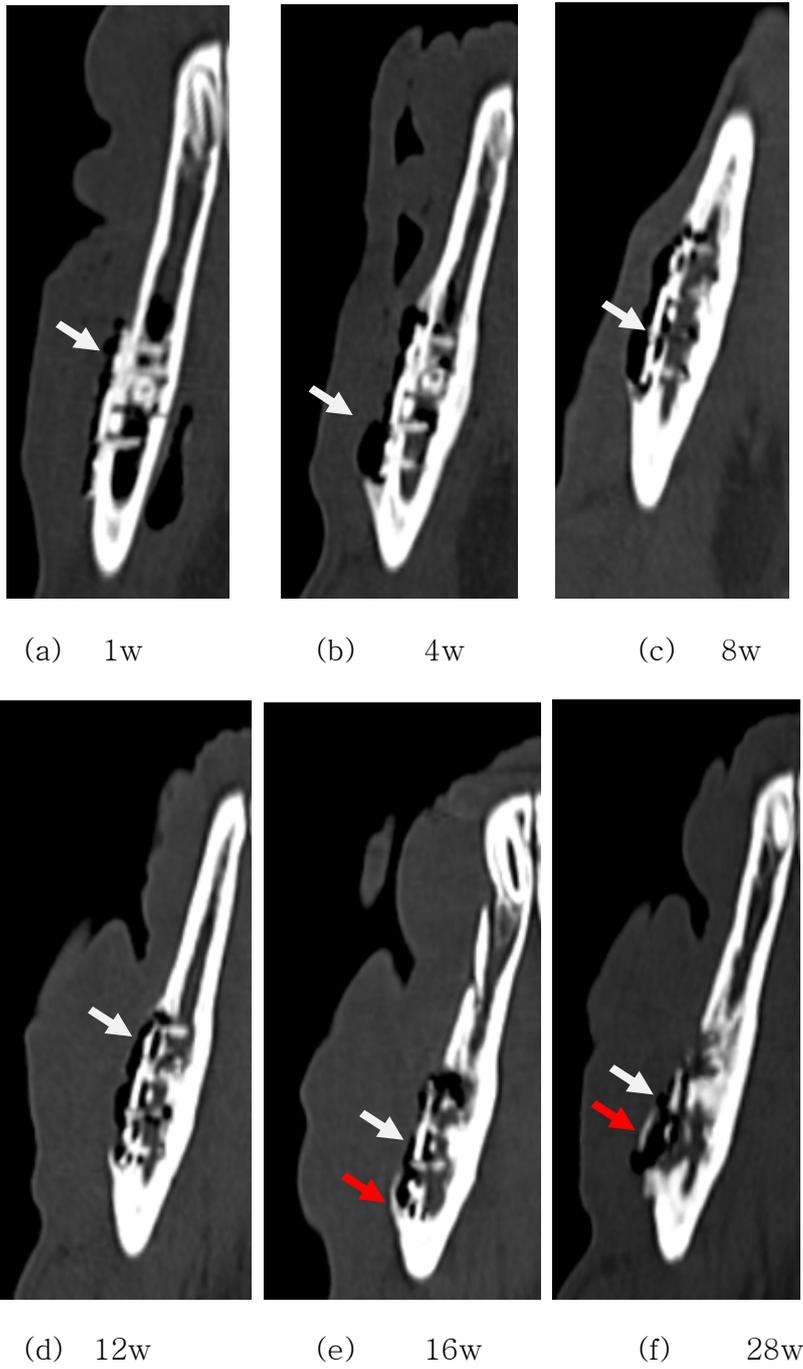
Computed tomography 2-dimensional view of magnesium plate and screw in the right mandible of beagle 1 showing local gas generation (white arrows) in ongoing device degradation and new bone formation (in (f), red arrow).
